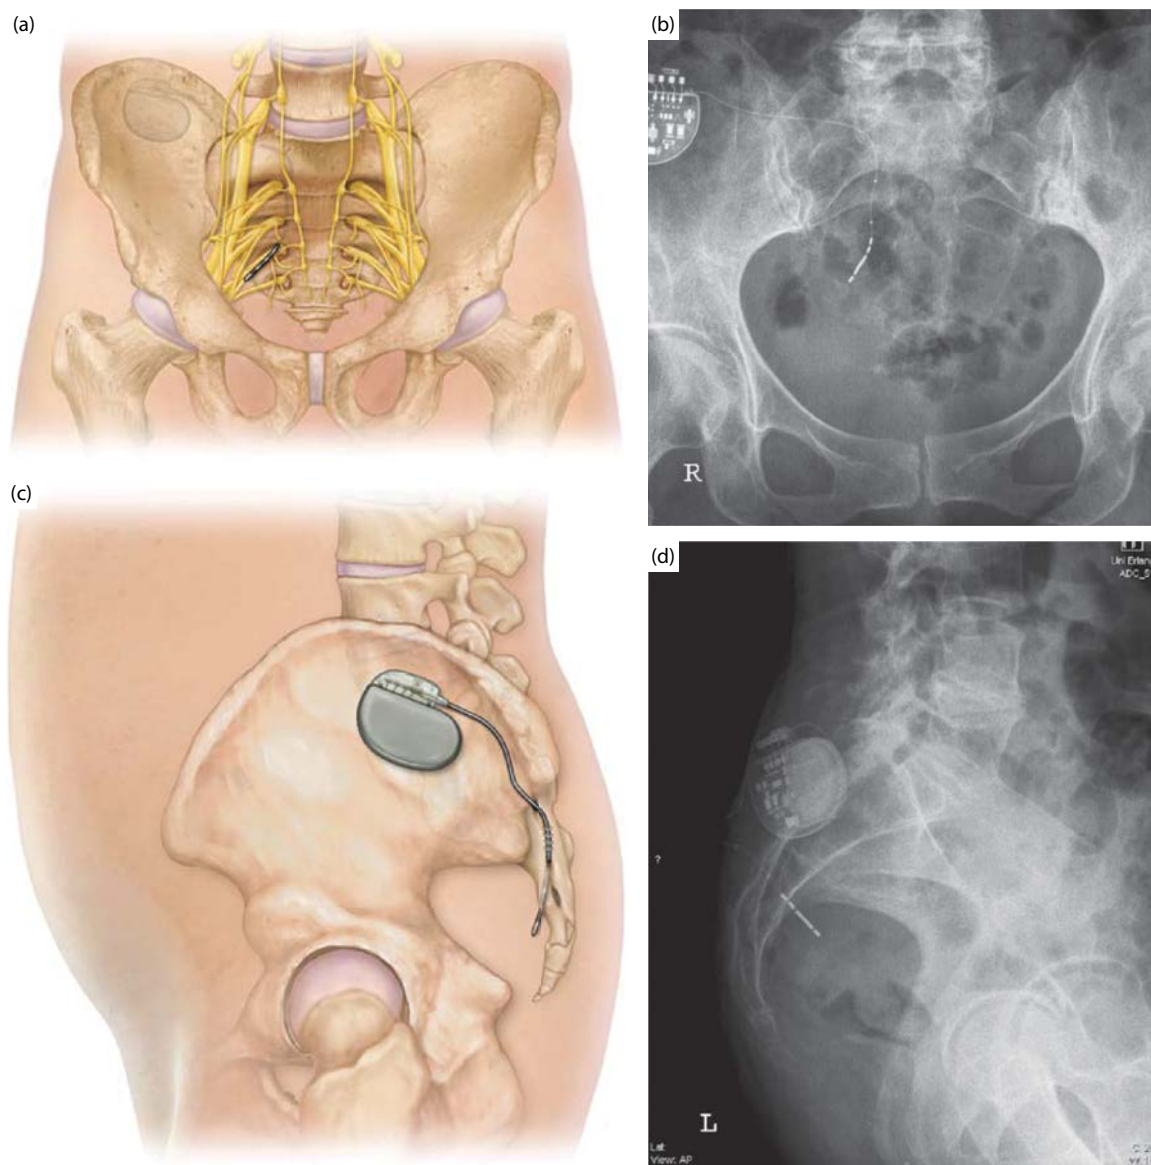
Lead position. (a) Anterior view, art work; (b) posteroanterior x-ray; (c) lateral view, art work; (d) lateral x-ray. (With permission from Wexner SD et al. [eds.]. *Colon and Rectal Surgery: Abdominal Operations [Master Techniques in Surgery]*. Philadelphia, PA: Lippincott Williams and Wilkins/Wolters Kluwer; 2011.⁶⁵)
